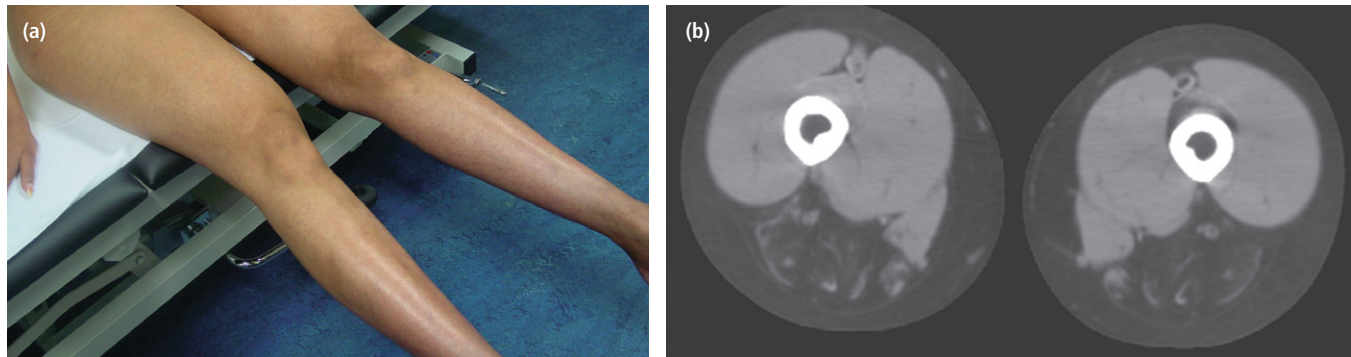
GNE-myopathy. (a) The patient is able to extend her legs due to relative preservation of the quadriceps muscles. (b) CT scan shows striking fatty replacement of the posterior thigh muscles by fat and sparing of the quadriceps muscles except for the rectus femoris muscles.
